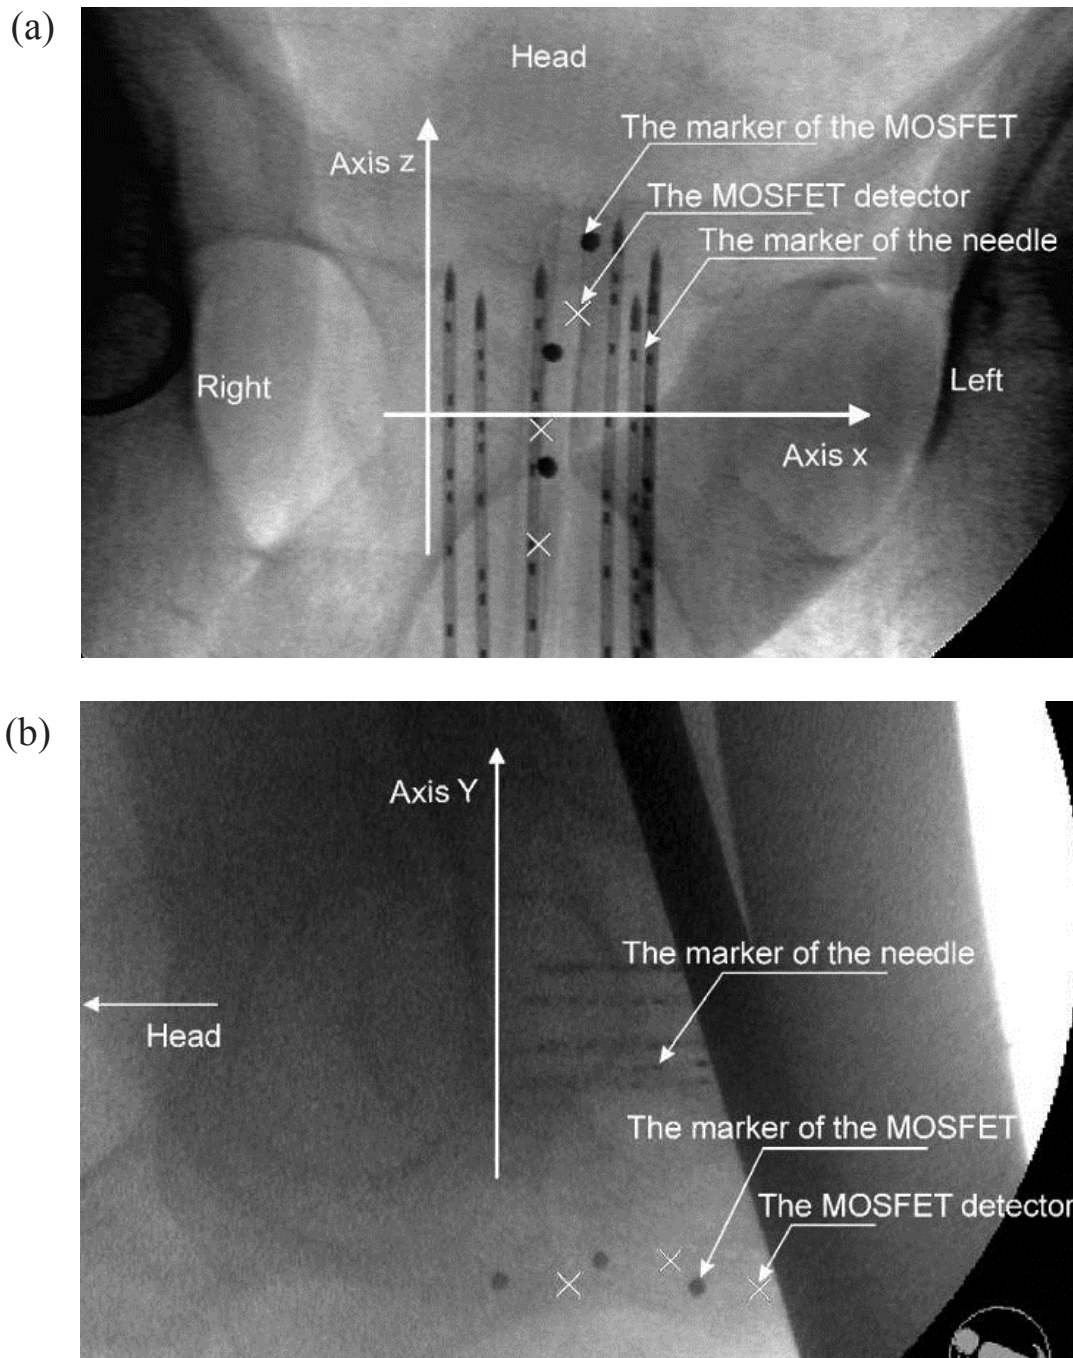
The AP and lateral (LT) radiograph.
